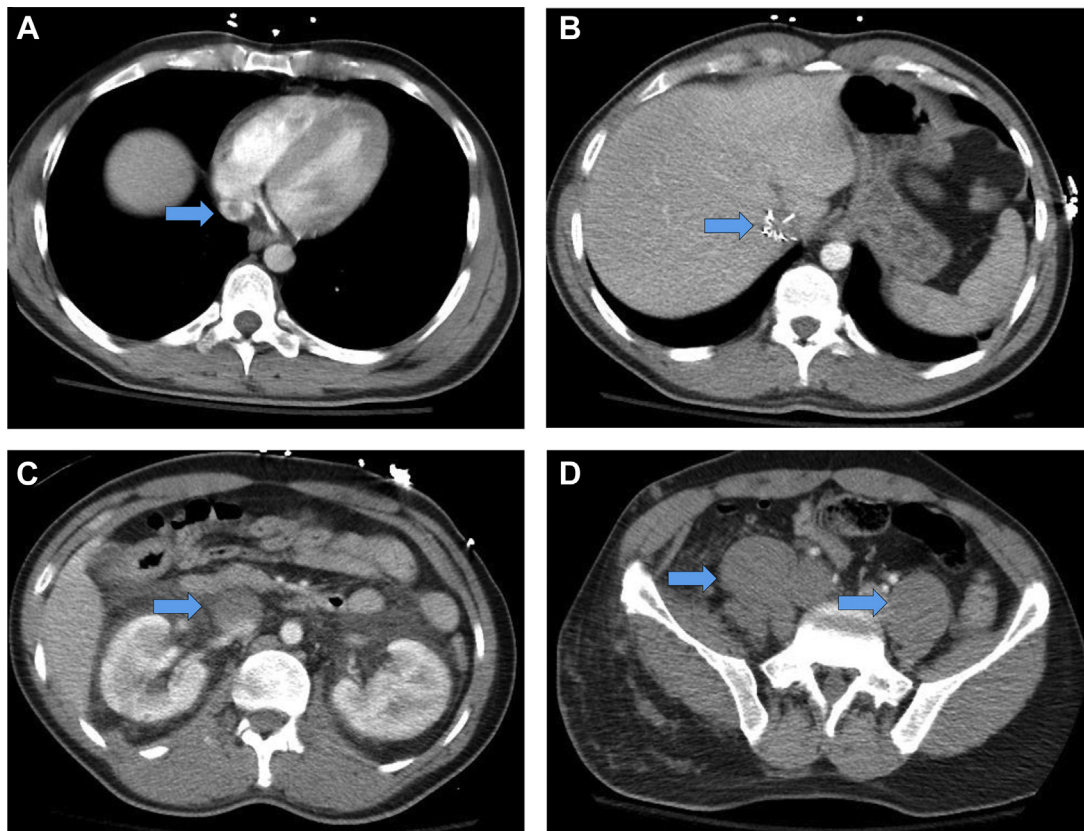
Axial cuts of computed tomography venography at different levels of the inferior vena cava (IVC) depicting extensive thrombus (*blue arrows*) at IVC–right atrium junction (A), suprarenal IVC region with filter (B), infrarenal IVC region, and bilateral dilated common iliac vein region (D).
